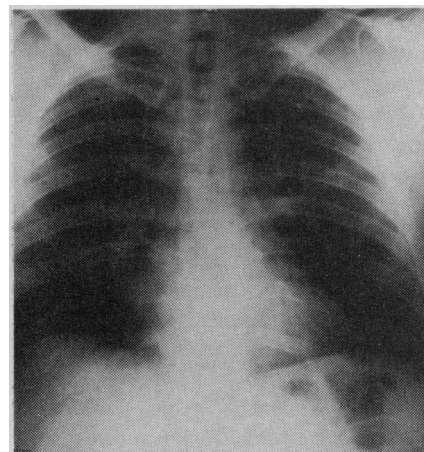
Chest radiograph of Case 1, March 10, 1969, at peak of symptoms. Widespread, evenly distributed bilateral disease with a mixed reticular and acinar pattern suggesting combined interstitial and airspace disease.
